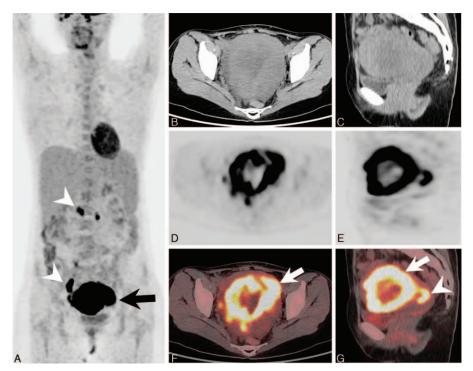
Maximum intensity projection PET (A) showed intense FDG uptake of the enlarged uterus (arrow) and multiple hypermetabolic lymph nodes (arrowheads) in the pelvis and retroperitoneum. Transverse CT (B, C), corresponding PET (D, E), and fused (F, G) images showed intense FDG uptake in the thickened wall of the uterine corpus (arrows) and cervix (arrowhead) with SUV_{max} of 26.9. CT = computed tomography, FDG = fluorodeoxyglucose, MRI = magnetic resonance imaging, PET = positron emission tomography.
